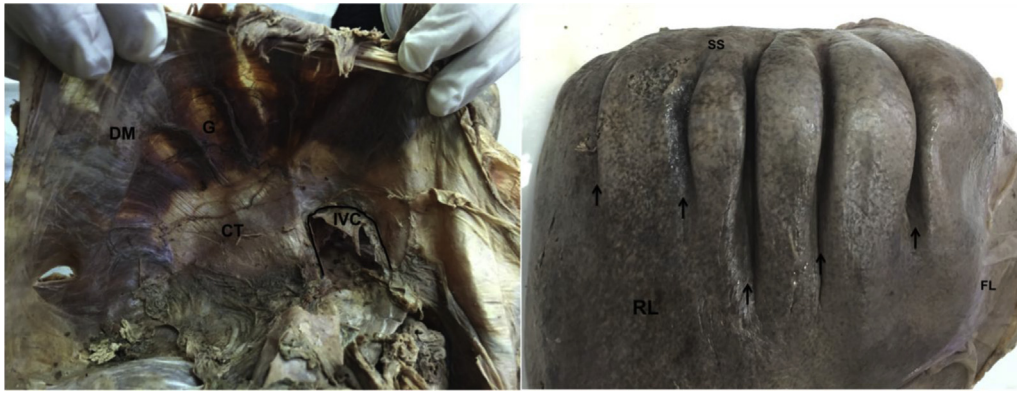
Photograph showing diaphragm and anterosuperior surface of liver. Abbreviations used: DM: diaphragmatic muscle; CT: central tendon; IVC: inferior vena cava; G: gap; SS: superior surface of liver; RL: right lobe; FL: falciform ligament. Black arrows represents diaphragmatic sulci.
